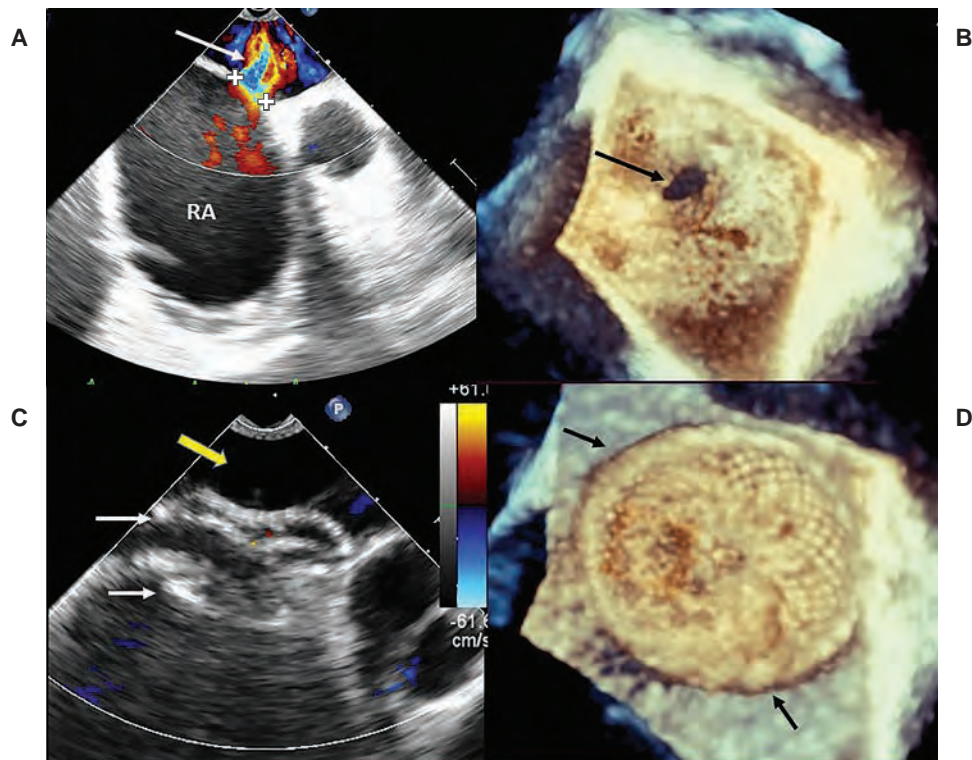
(A) Transoesophageal echocardiographic image of the atrial septal defect (iASD) denoted by "+". The shunt from the right atrium (RA) to the left atrium (LA) is demonstrated on colour Doppler (arrow). (B) 3-dimensional transoesophageal echocardiographic image of the iASD (arrow). (C) Transoesophageal echocardiographic image of the iASD after Amplatzer device closure. The white arrows denote the 2 discs straddling the interatrial septum and the yellow arrow denotes no residual shunt into the LA. (D) 3-dimensional transoesophageal echocardiographic image of the iASD after Amplatzer device closure. The arrows denotes the device disc viewed from the LA.
